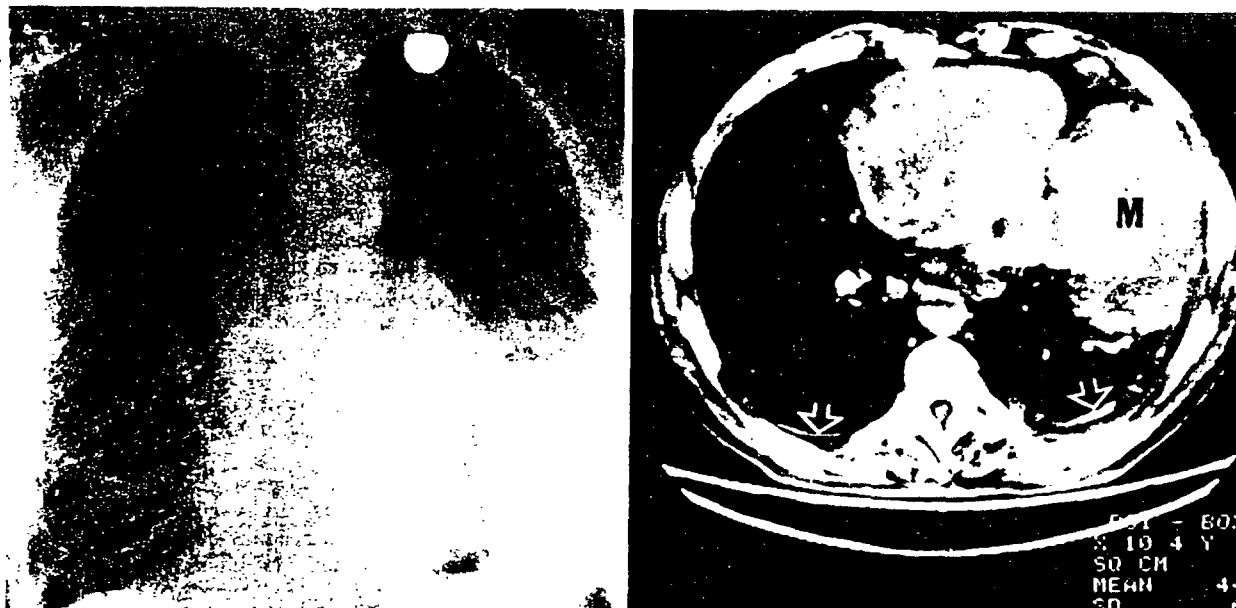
Left, In this posteroanterior roentgenogram of chest, considerable dense, linear, interstitial thickening is noted in lower half of right lung (asbestosis). Costophrenic angle is blunted and pleura is thickened to level of posterior segment of third rib. On left side, upper lobe nodule as well as homogeneous opacification of lung base is present. Differential diagnosis included loculated effusion, mesothelioma, and lung cancer. Right, Computed tomographic scan through lung base demonstrates large, left lower lobe lung mass (M), bilateral pleural thickening, and calcification (arrows) (oat cell carcinoma, left lower lobe).
